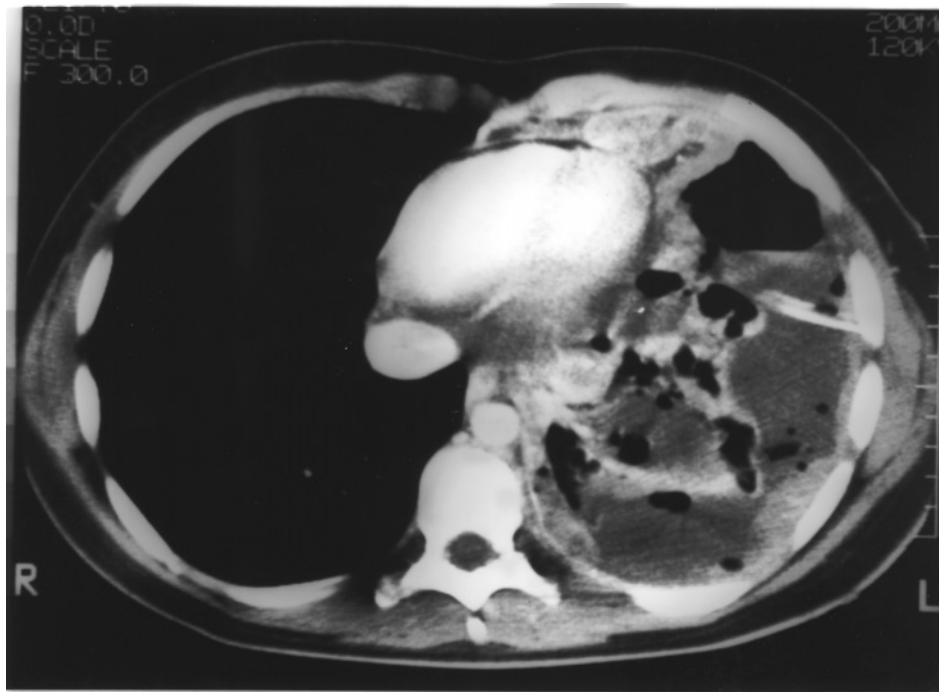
Computed tomography scan in Patient 2 showing a left large pleural mass with compression of the lung. Used with permission (30).
